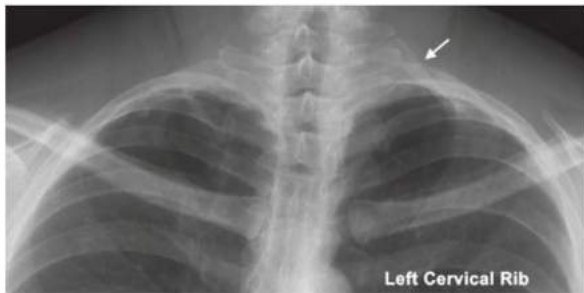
• A left-sided cervical rib identified by plain chest radiography (arrow).
